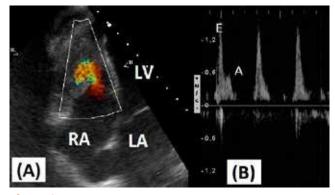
Panel A – Color Doppler shows turbulent flow in the right ventricle caused by the obliteration of its cavity and by high RV filling pressure. Panel B – Pulsed Doppler shows restrictive right ventricular filling pattern
